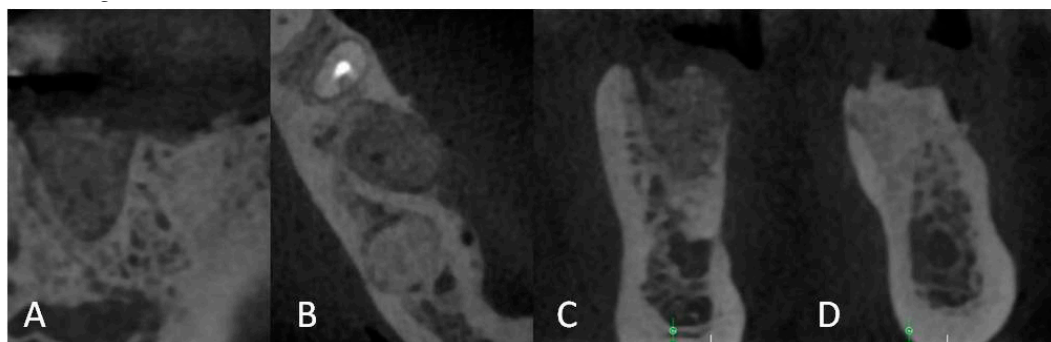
Postoperative 3D radiographic analysis (Acteon X-Mind Trium) in (A) sagittal and (B) axial projection, and cross-sections of Regions (C) 35 and (D) 36.
